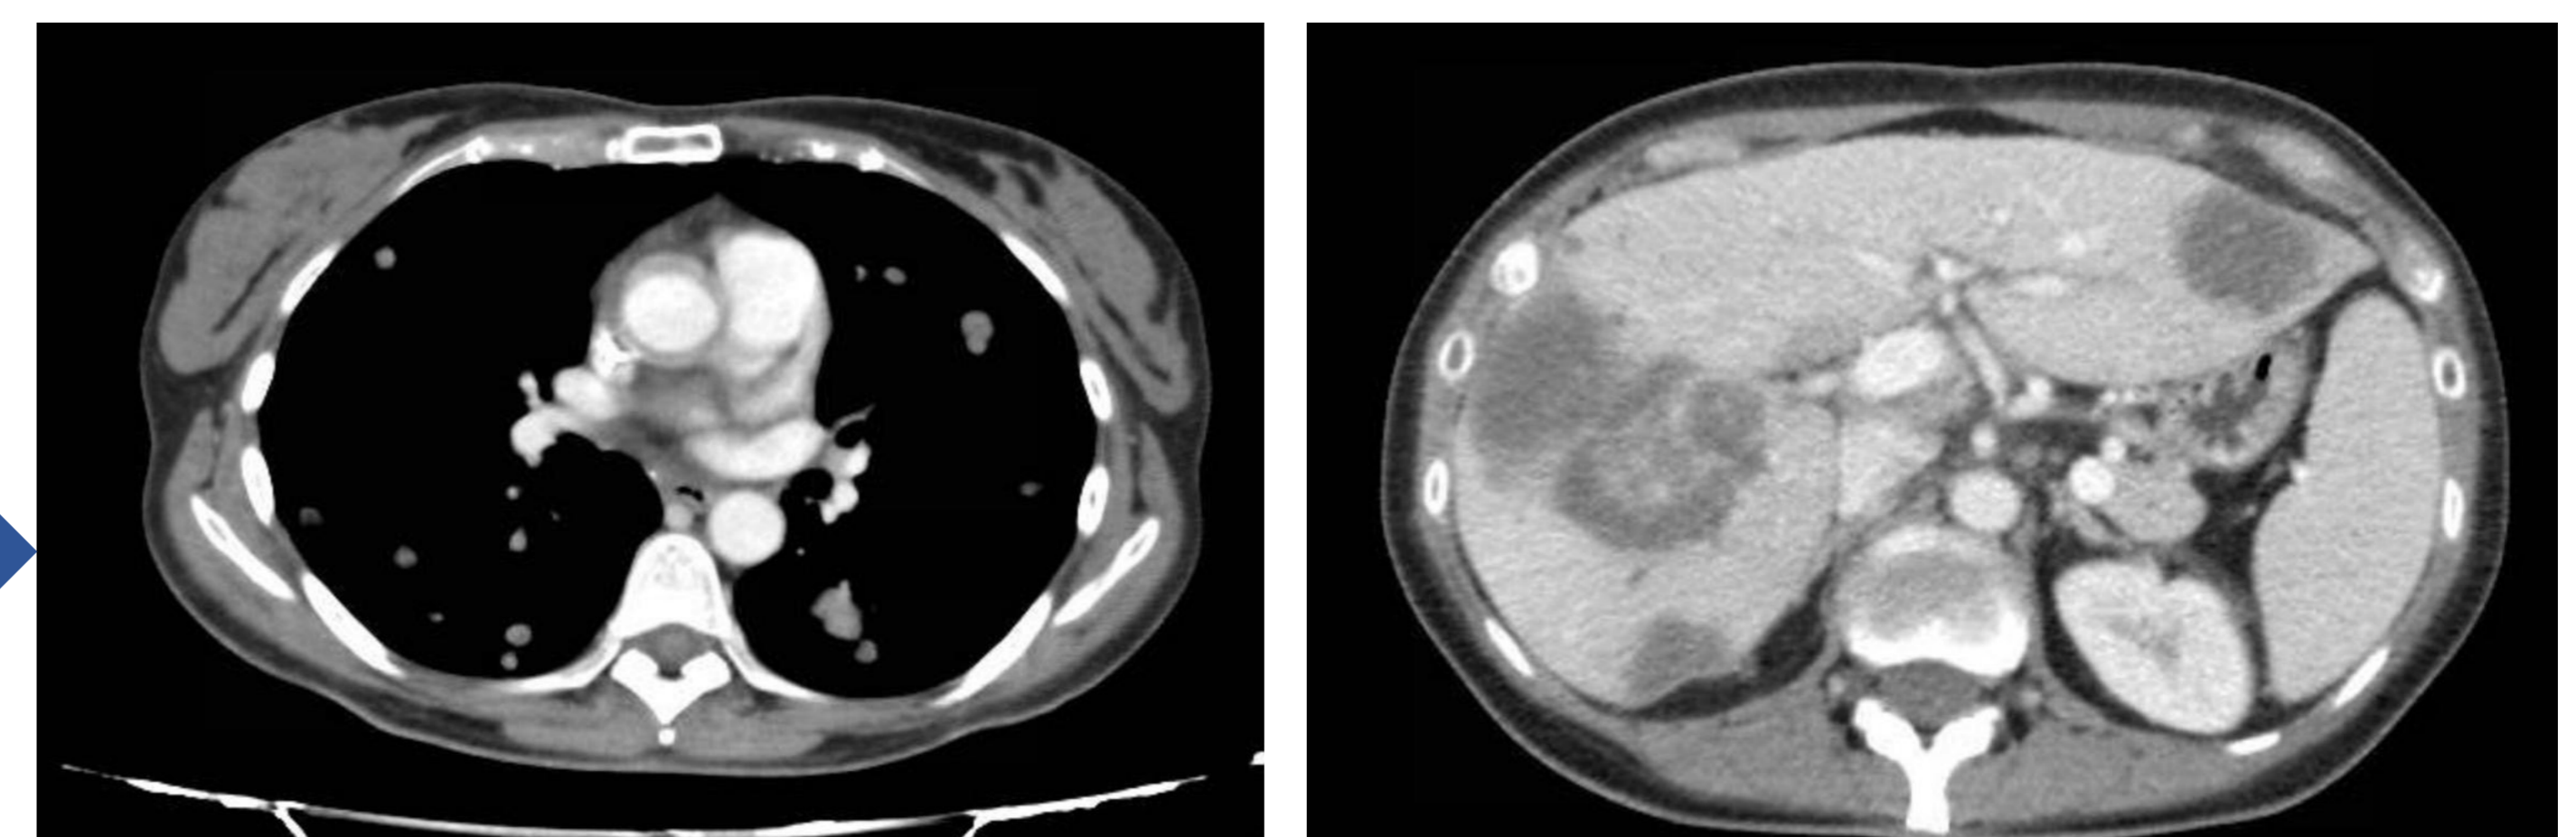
Basal CT scan showing pulmonary and hepatic lesions the present case - a PIK3CA H1047R mutated MMR stable stage IV left-sided adenocarcinoma of the colon - prior to nivolumab, ipilimumab and trametinib start.
